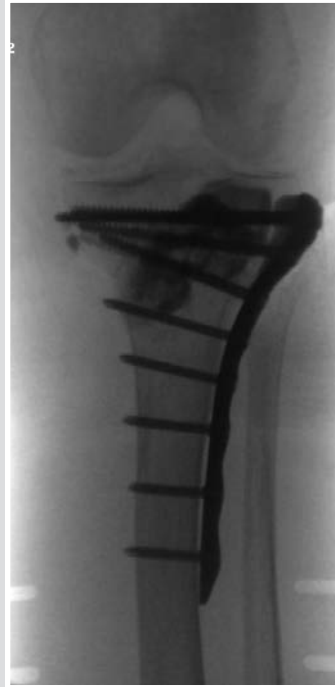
Intra operative anterior radiograph placement of CERAMENT™|BONE VOID FILLER
